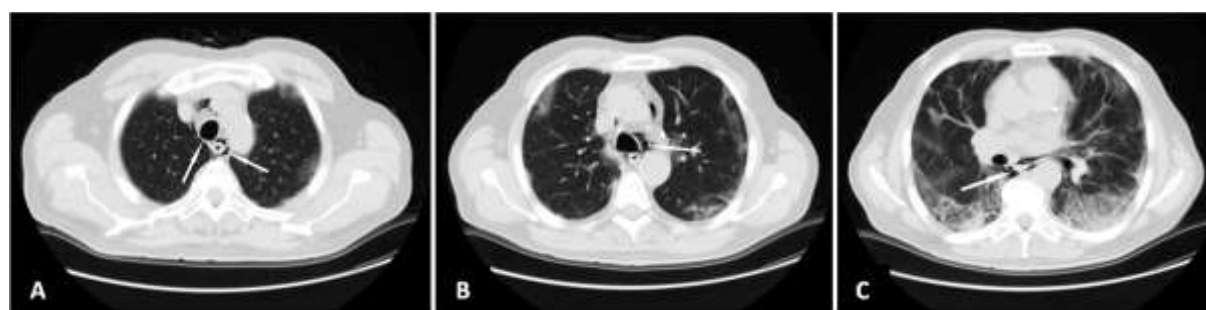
Axial CT chest images showing bilateral ground-glass opacities, predominantly in peripheral (A, B) and lower regions of the lungs (C).
